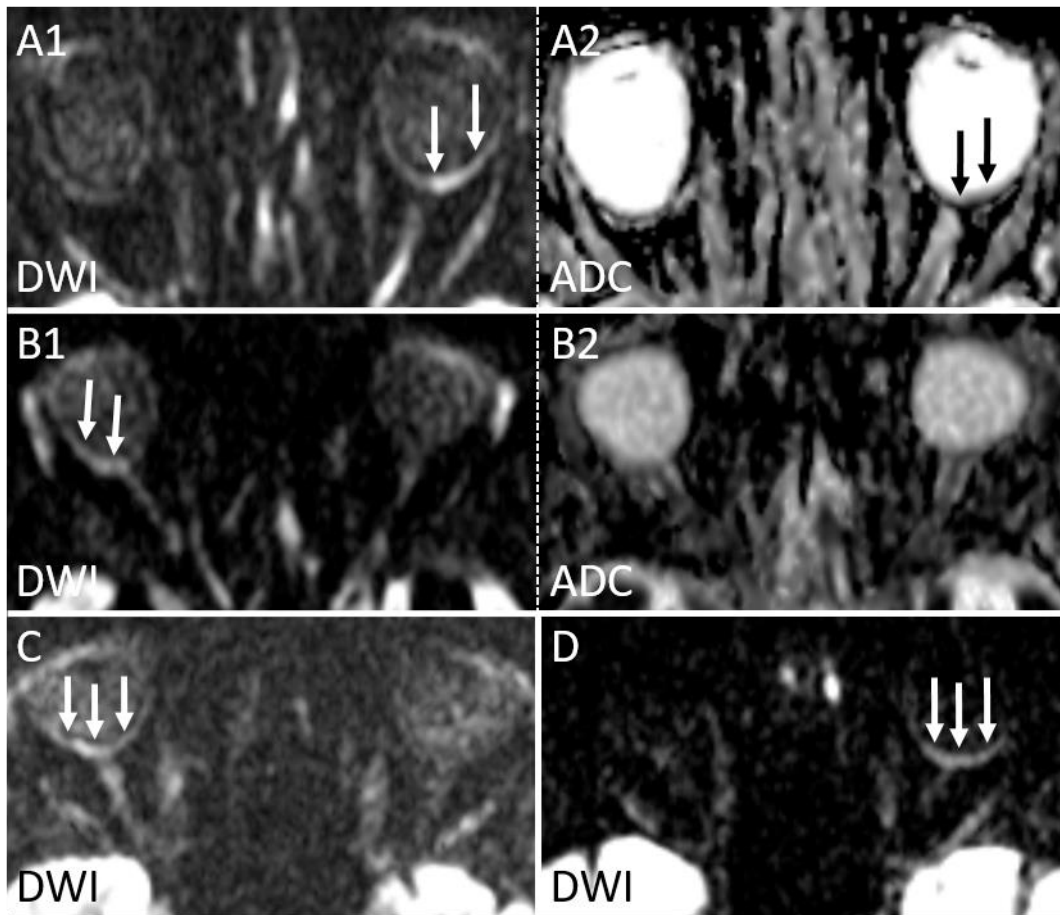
Examples of positive 1.5T DWIs in acute CRAO (traced DWI $b=1000 \text{ s/mm}^2$ and corresponding ADC). Case 1 (A1, A2): DWI-EPI MRI, left-sided CRAO with RDR and ADC reduction. Case 2 (B1, B2): DWI-EPI MRI, right-sided CRAO with RDR but no clear-cut visual ADC reduction. Case 3 and 4 (C, D): 2 DWI-EPI MRIs with RDR corresponding to the side of CRAO occlusion, but no clear-cut visually determinable ADC reduction (ADCs not shown). Note that due to reduced image quality and low contrast in the orbits, very narrow windowing was necessary to appreciate the DWI hypersignal.
